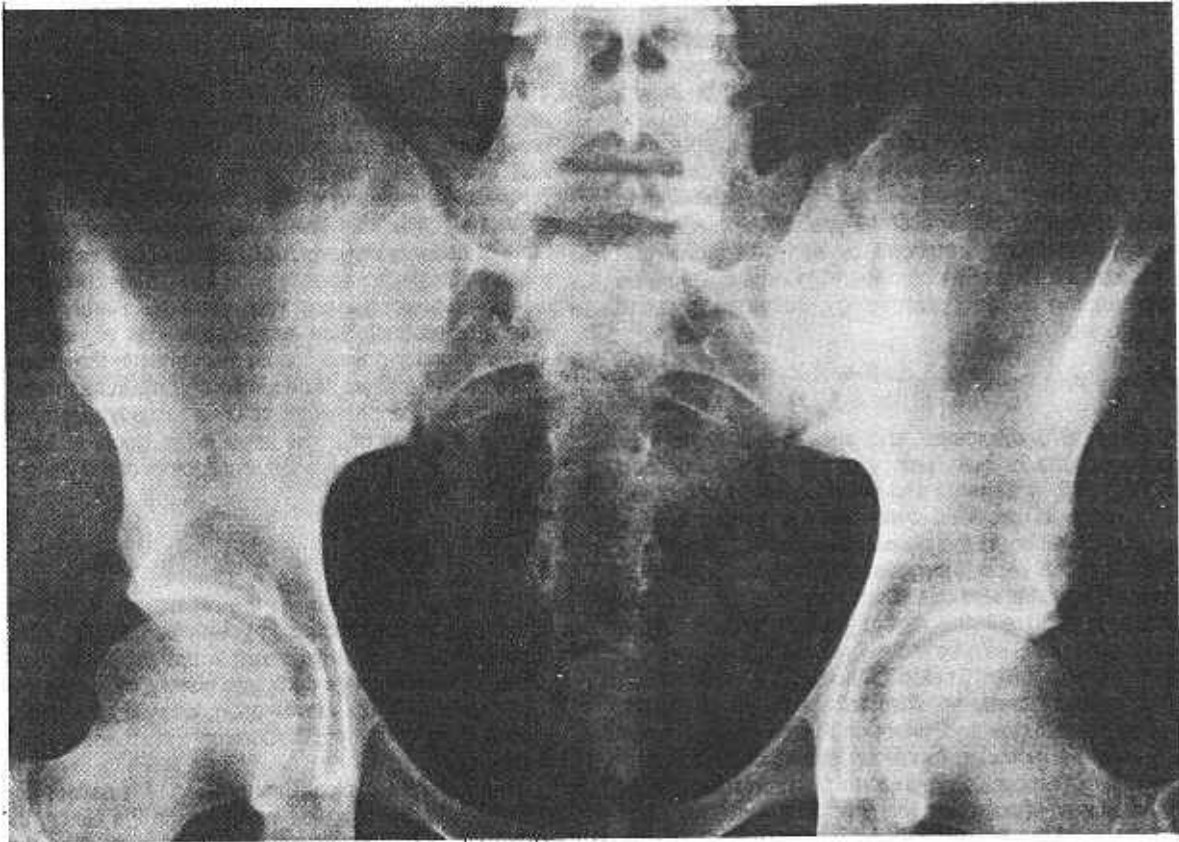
X-ray of the pelvis discloses pseudowidening of the sacroiliac joints from subchondral erosions and sclerosis that are more prominent on the iliac side.
